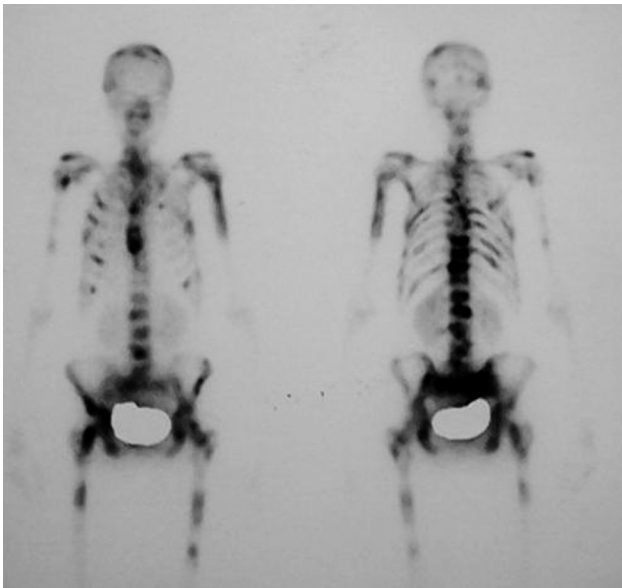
Technetium-99m MDP bone scintigraphy showed metastatic involvement of skull, vertebral column, bilateral femur and 1/2 proximal humerus
